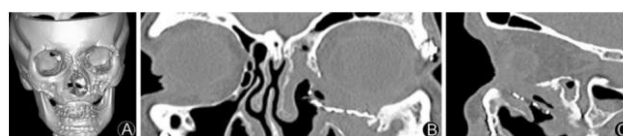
A: A history of extensive face reconstruction was found during the preoperative CT reconstruction. B: An axial CT scan of the orbital bone, with soft tissue displacement caused by infection, was shown. C: A sagittal CT scan of the skull showed that defective hardware was encroaching on the region of the maxillary sinus.
